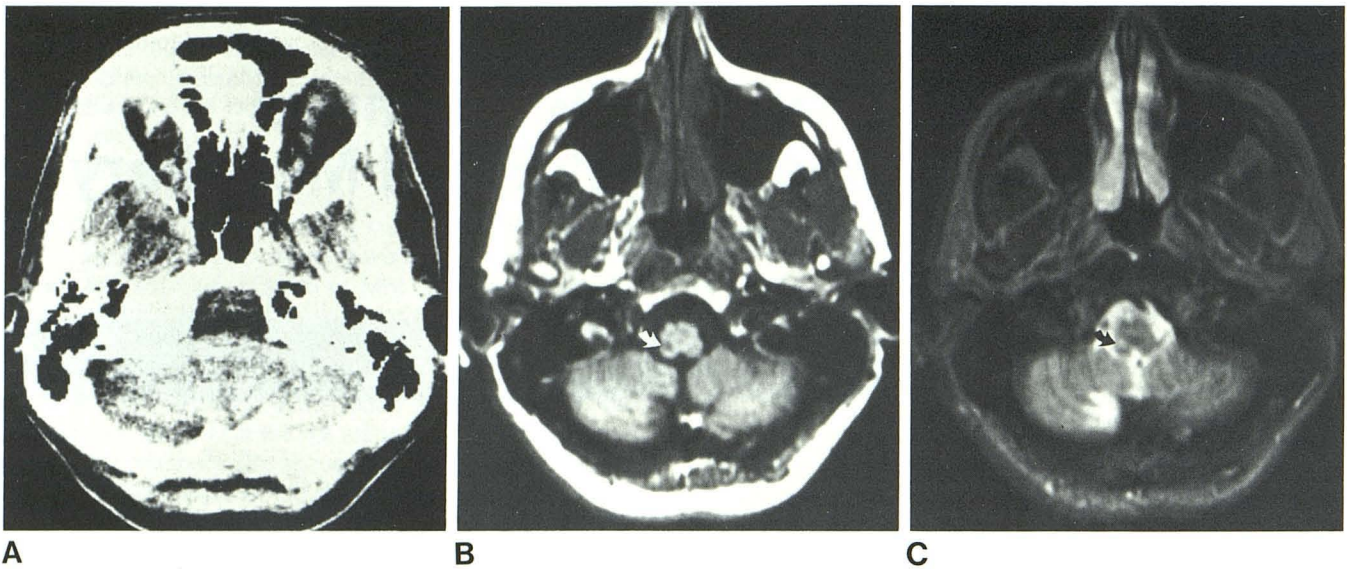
50-year-old woman with moderate recovery from right lateral medulla infarction 17 months earlier. Angiography showed intracranial right vertebral occlusion. A, Unenhanced CT scan through medulla. Beam-hardening
